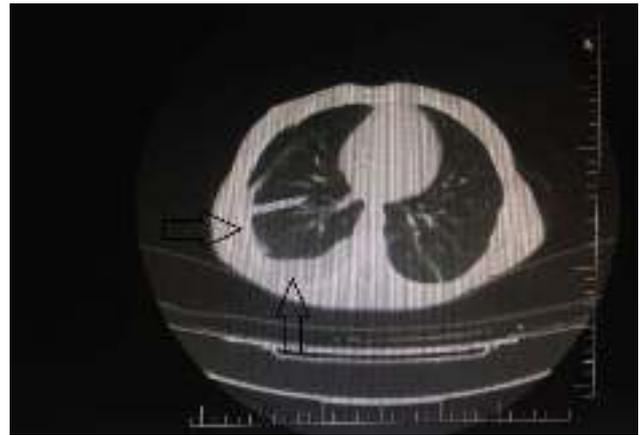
CT images of the chest - Arrows show pleural thickening due to pleural metastasis and hemothorax
